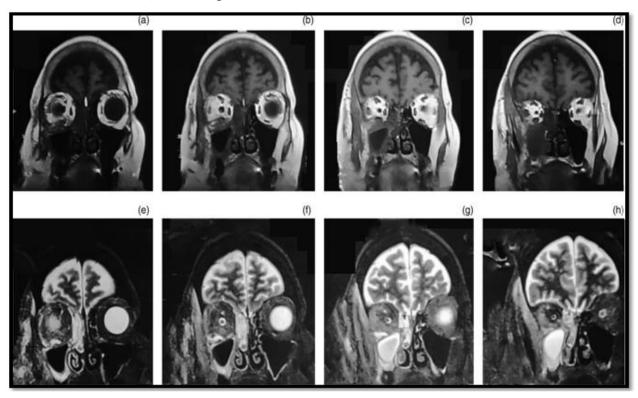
Mucormycosis Report MRI.
